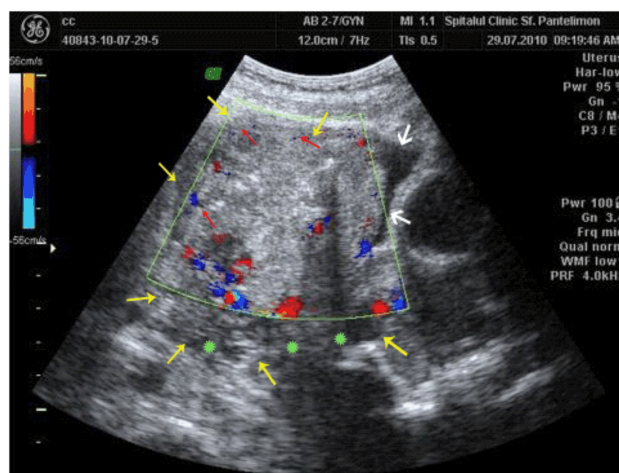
Sagittal sonogram demonstrating severely enlarged uterine cavity, heterogeneous echogenic mass (yellow arrows), absent subendometrial halo (red arrows), myometrial invasion (green stars), large areas of hemorrhage and strong color Doppler signal in the echogenic mass (white arrows).
